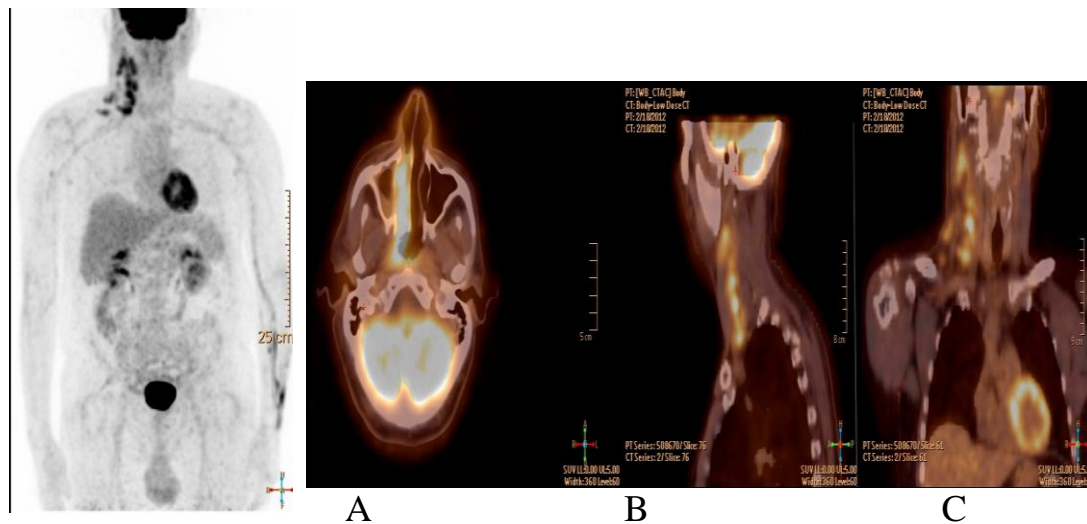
A 63-year-old man with newly diagnosed NPC, FDG PET/CT done for staging. FDG PET MIP (a) and fused FDG PET/CT axial (b), sagittal (d) and coronal images (c) for the head and neck region showed metabolically active nasopharyngeal tumor with multiple metabolically active right cervical metastatic lymph nodes. Otherwise there is no distant metastasis.
